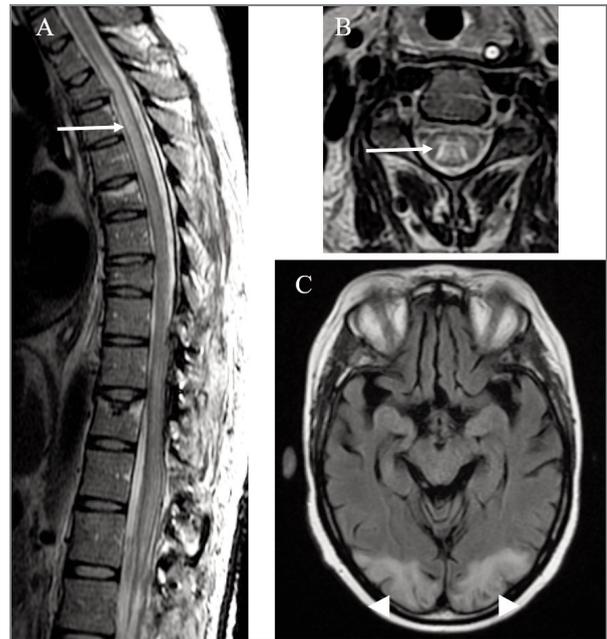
A and B (MRI in T2 FSE sequence) show abnormal hyperintense signal of spinal cord (arrow), at C4 axial level (A) and extending longitudinally through thoracic spinal cord (B). C (MRI in T2 FLAIR sequence) shows bilateral occipital cortical and subcortical white matter hyperintensities (arrowhead), compatible with posterior reversible encephalopathy syndrome
